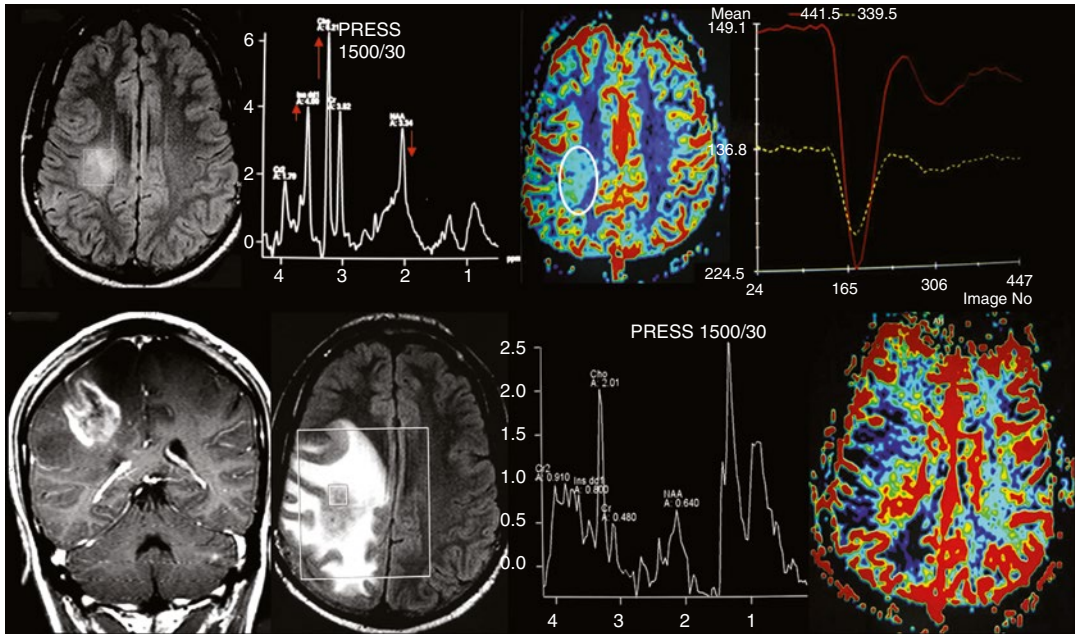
A 21-year-old man with left hemiplegia and seizures, with a biopsy proven low-grade glioma. Presurgical MRI (*top row* images) demonstrated an infiltrative lesion on FLAIR image, with increased perfusion on DSC-MRI. MRS shows elevation of choline and myo-inositol as well as a reduction of NAA, typical of low-grade gliomas. Some months after surgery, the patient got
